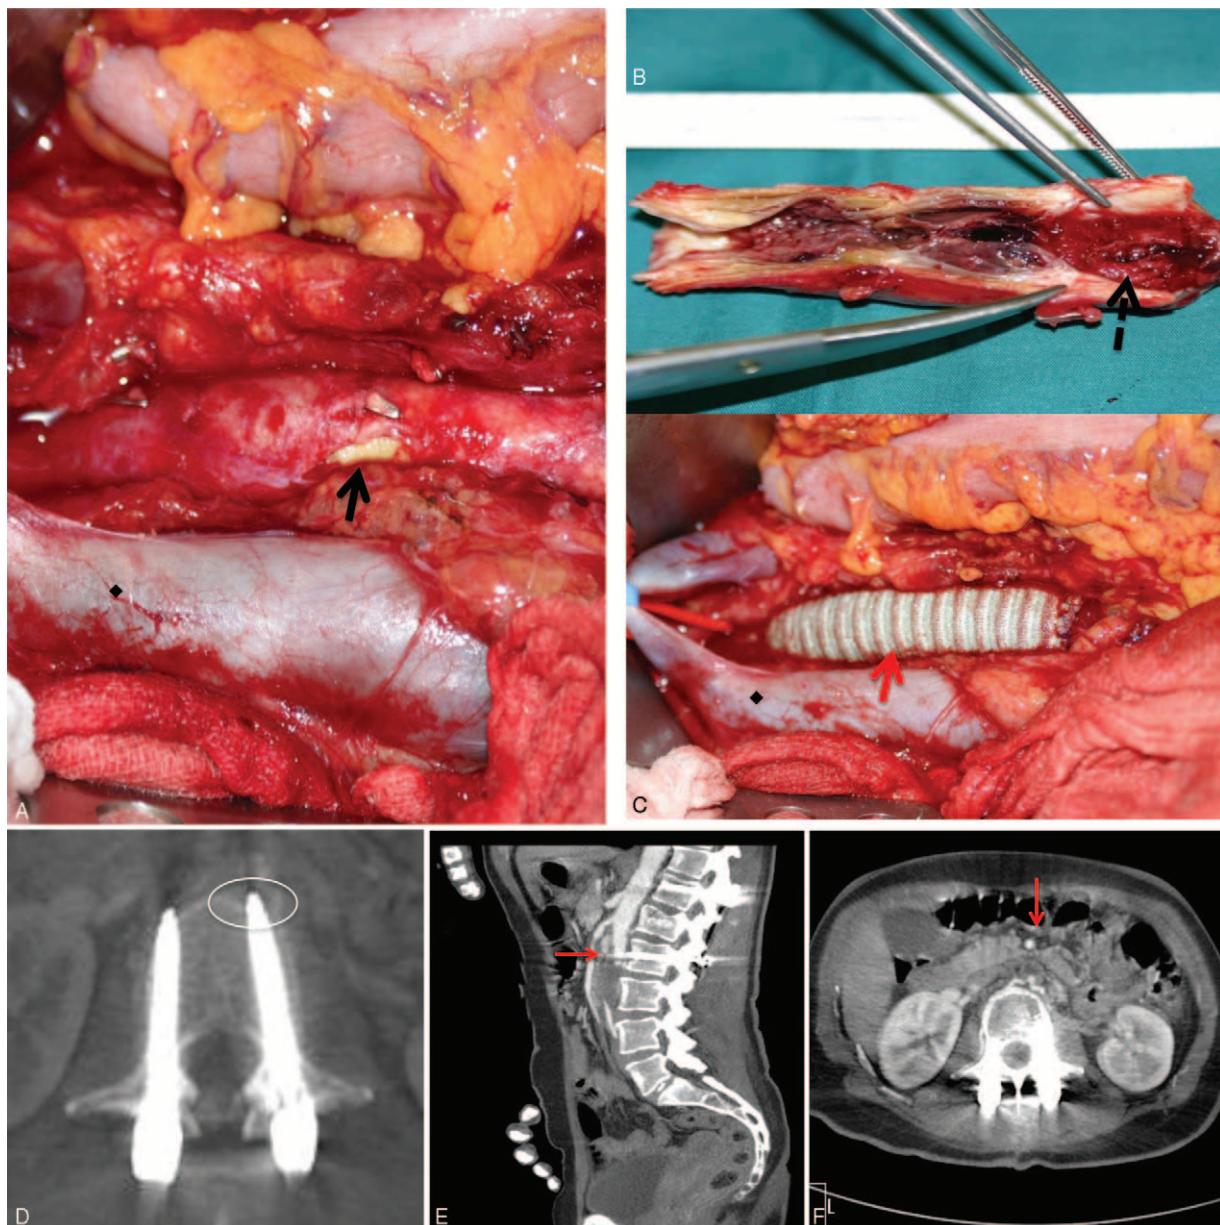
(A) Intraoperative situs of the abdominal aorta. Black arrow indicates location of the thrombus. (◆) Indicates the vena cava. (B) Shows the opened resected aorta. Dotted arrow indicates the thrombus. (C) Red arrow indicates the implanted graft. (◆) Indicates vena cava. (D) Postoperative radiographs after bisegmental posterior instrumentation T12–L2 for an unstable L1 burst fracture (AO 3.1) with obvious pedicle screw malpositioning in CT-scan. (E,F) CT-angiography shows complete obliteration of the abdominal aorta indicated with red arrow without contrast enhancement of the abdominal aorta below the renal artery.
